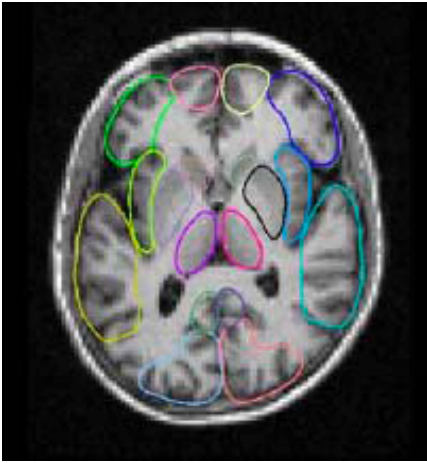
Automatic user-independent delineated regions of interest at the slice of an MRI (Svarer et al., 2005)
